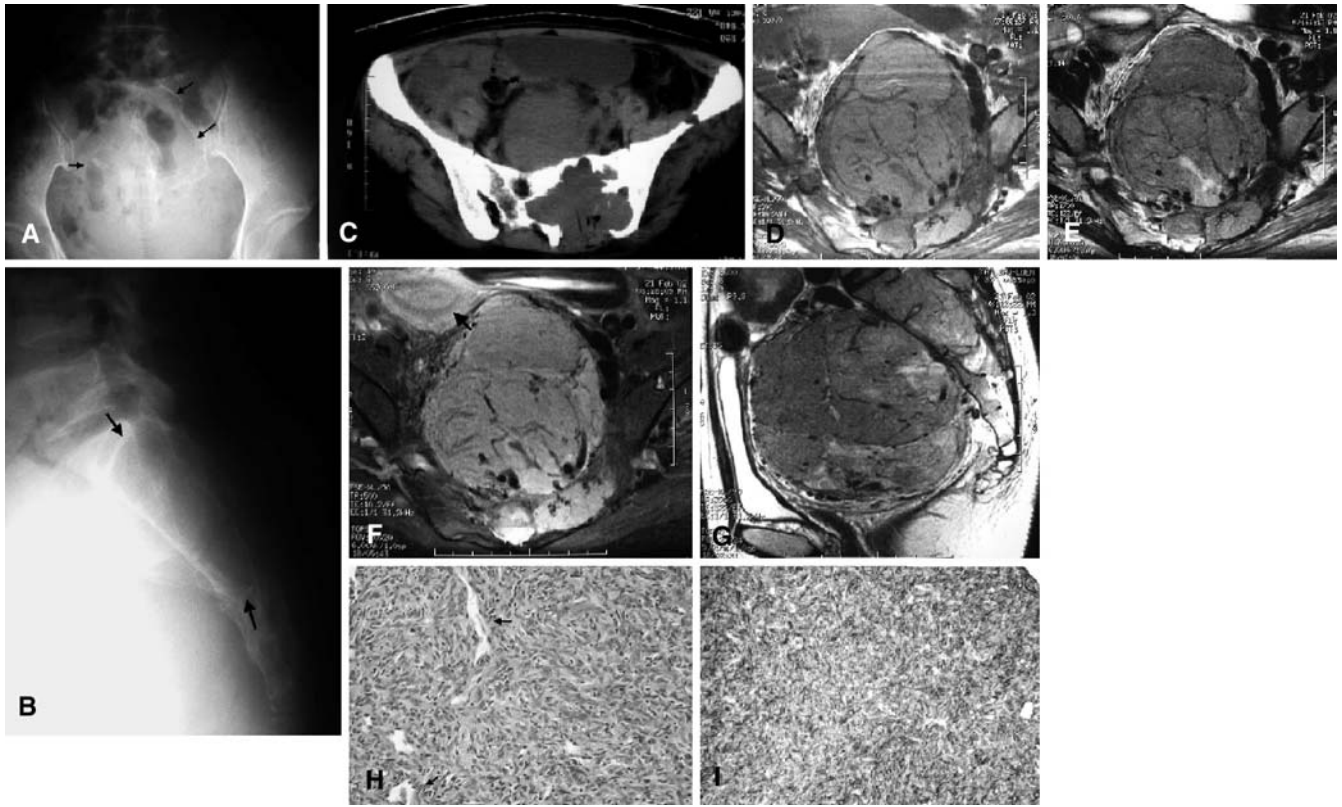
A Anteroposterior and B lateral radiographs of the sacrum show a destructive osseous lesion (*arrows*) in the sacrum. C CT scan of pelvis after biopsy shows no calcifications within the osteolytic bony lesion. The tumor has air due to being post-biopsy. D Axial T1-weighted (TR/TE=500/10.2 ms), and E axial T2-weighted (TR/TE=3700/122 ms) MR images show a well-demarcated soft-tissue mass in the sacrum with anterior extension to the pelvic cavity. Note signal-void tubular vascular structures within the tumor. F Gadolinium-enhanced T1-weighted (TR/TE=500/10.2 ms) image with fat saturation shows marked enhancement of the tumor. The curvilinear structures are arranged radially as a “spoke-wheel” pattern within the tumor. The vascular channels do not enhance
